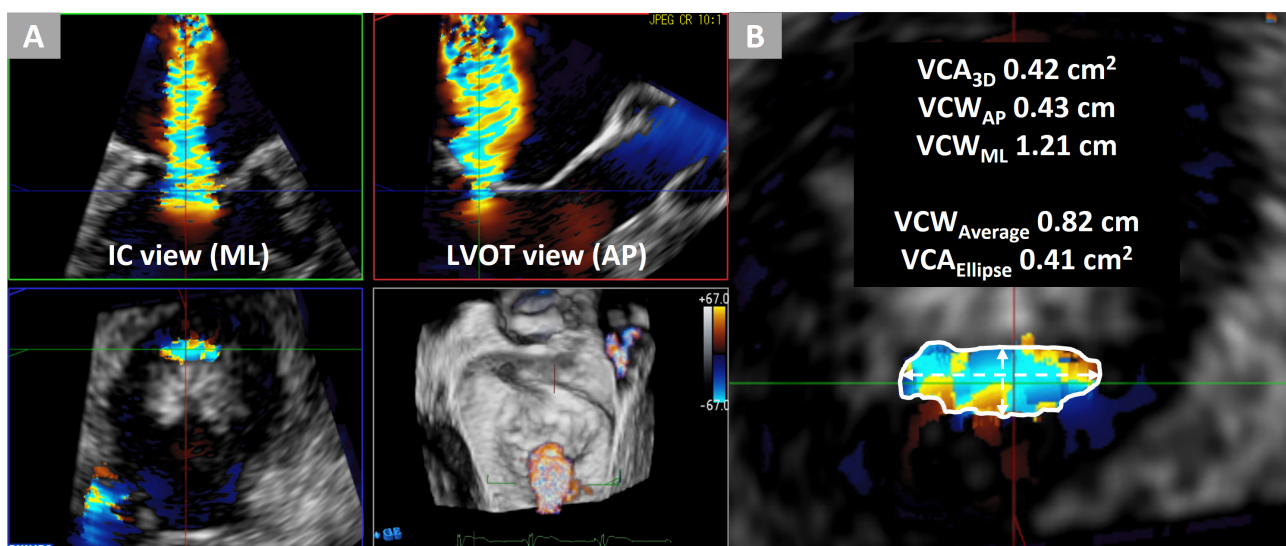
Assessment of vena contracta using 3D-TEE. A case of an 84-year-old woman with dilated cardiomyopathy and secondary mitral regurgitation. (A) Vena contracta described by multiplanar reconstruction of 3D color Doppler datasets. (B) VCA_{3D} measured using manual planimetry of the vena contracta was 0.42 cm^2 . VCW_{AP} and VCA_{ML} measured as the narrow and wide VCWs in the anteroposterior and mediolateral directions were 0.43 and 1.21 cm, respectively. $VCW_{Average}$, calculated as $(VCW_{AP} + VCW_{ML})/2$, was 0.82 cm. $VCA_{Ellipse}$, calculated as $\pi \times (VCW_{AP}/2) \times (VCW_{ML}/2)$, was 0.41 cm^2 . IC, intercommissural; LVOT, left ventricular outflow tract; 3D-TEE, three-dimensional transesophageal echocardiography; VCA_{3D} , three-dimensional vena contracta area; VCW_{AP} , anteroposterior vena contracta width; VCW_{ML} , mediolateral vena contracta width; $VCW_{Average}$, average of anteroposterior and mediolateral vena contracta widths; $VCA_{Ellipse}$, vena contracta area as an ellipse.
